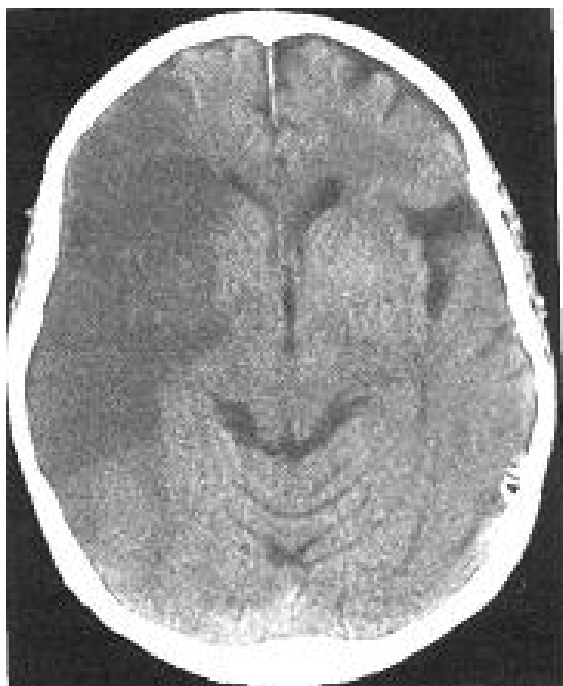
CT scan of the brain (after 72 hours). Territorial stroke in the pool of the right midbrain artery. On a CT scan in the right frontal, temporal and parietal lobes, a zone of reduced density is determined up to 20-22 HU, with a relatively clear contour, the furrows are not clearly differentiated. The boundary between gray and white matter is not defined. The islet gyrus does not differentiate. The middle structures are shifted to the right by 6 mm, with compression of the left lateral ventricle, signs of lateral and axial dislocation of the brain are determined.
